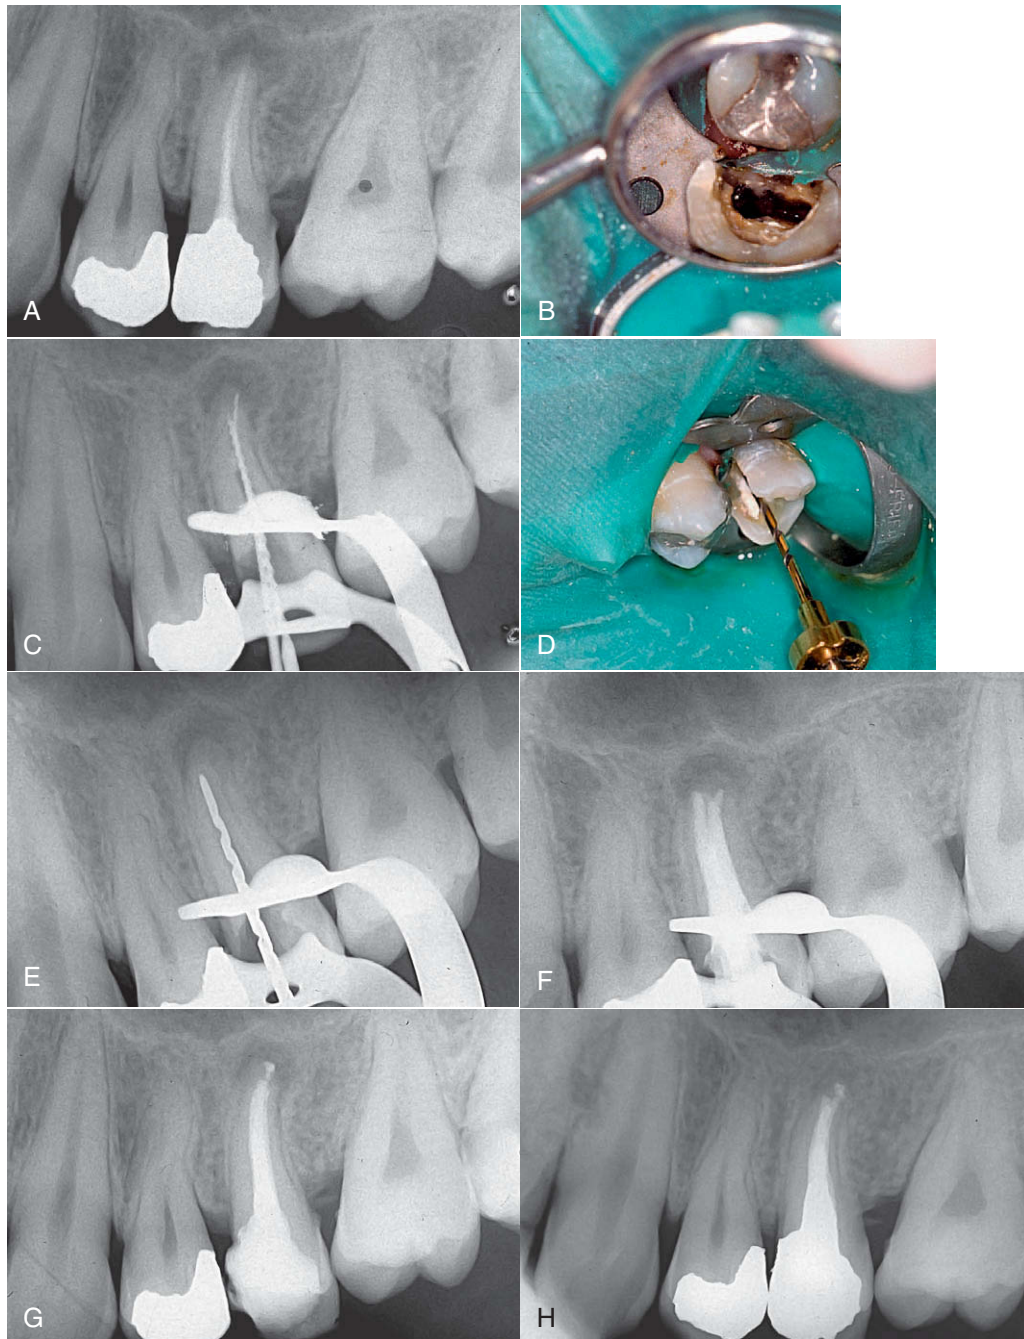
• A, Preoperative radiograph of second left maxillary premolar with chronic apical periodontitis. A periapical radiolucent area can be clearly seen; root canal re-treatment is indicated. B, After access opening, previous root canal filling material was removed; occlusal view shows unclean root canals. C, Length measurement radiograph shows two separate root canals. D, Using Er:YAG laser irradiation for cleaning of root canal system. RCLase Side Firing Spiral Tip is introduced to root canal after completion of biomechanical preparation of canal with NiTi (ProTaper) files. E, RCLase tip in root canal. F, Master point radiographs showing both root canals filled with gutta-percha. G, Completed endodontic therapy. H, Six-month postoperative radiograph shows good repair.
